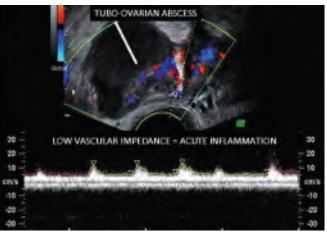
Transvaginal color Doppler scan of a tuboovarian abscess. Note prominent vascularization and low impedance blood flow signals obtained from the tubal walls and incomplete septations
